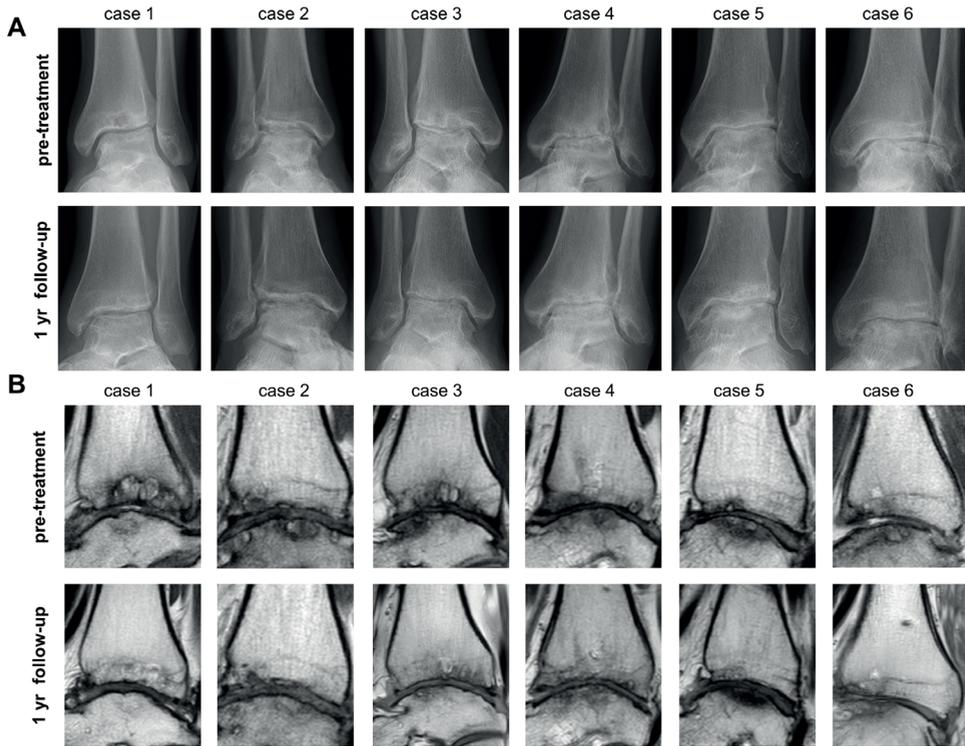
Structural changes on X-ray and MRI
